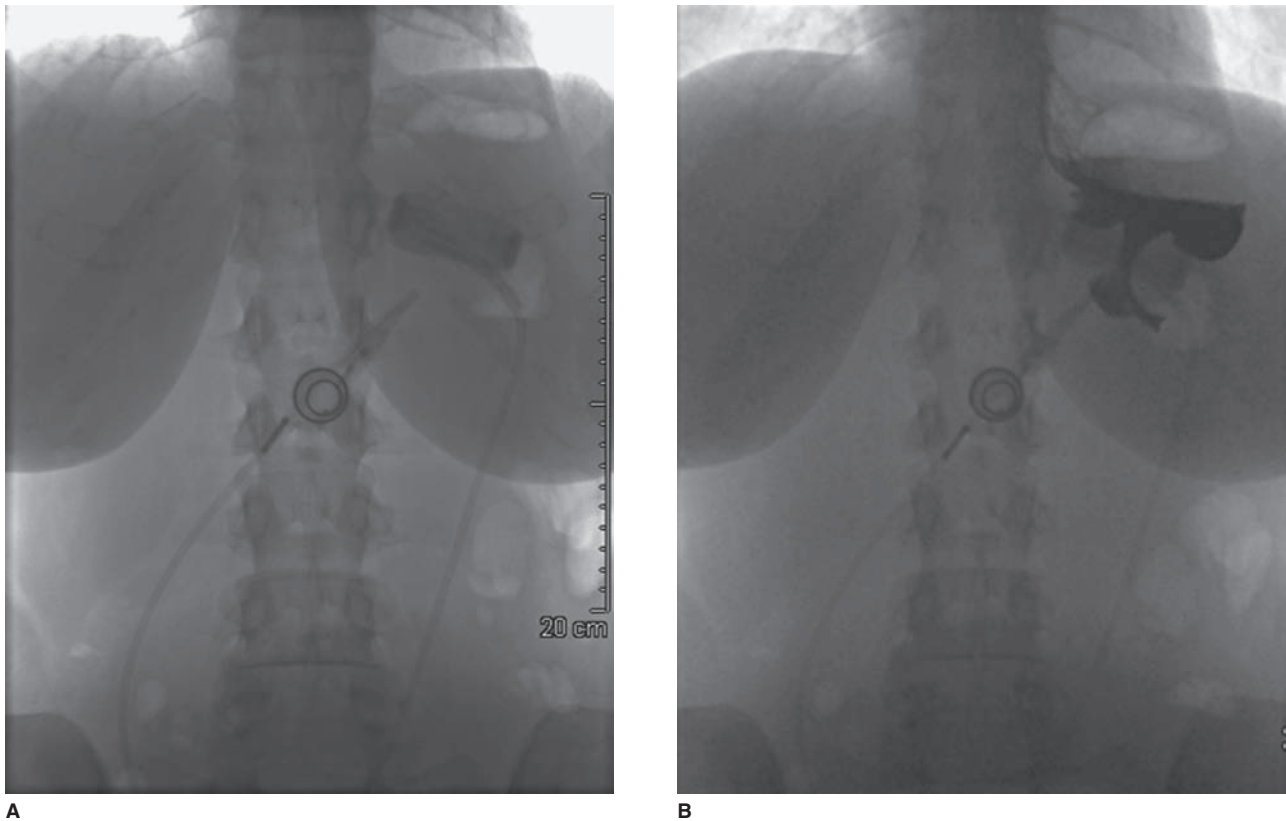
A. Picture of a plain film of a prolapsed band with the port flat. B. Picture of UGI showing band prolapse.
